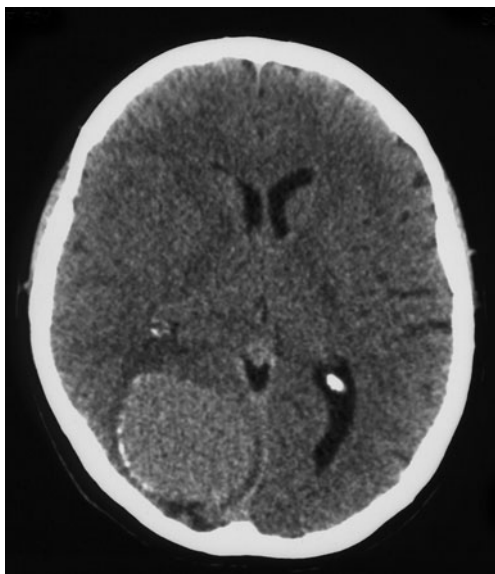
Initial computed tomography showing an important round hyperdense occipital mass, 6 cm diameter
